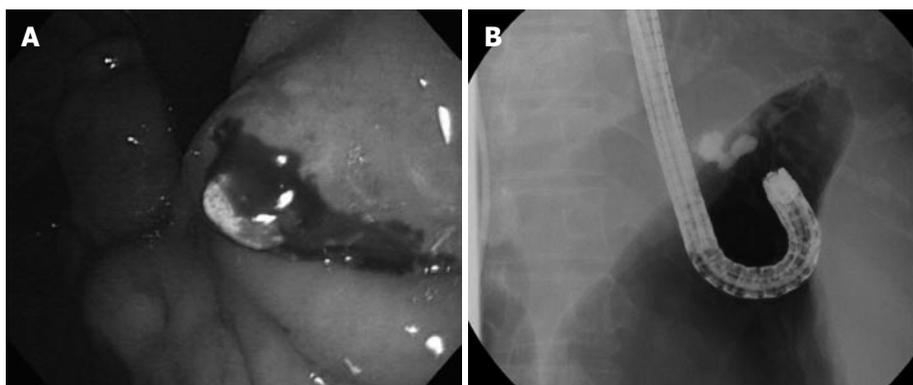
Endoscopic examination at the time of cardiac variceal rupture. A: Endoscopic examination revealed active bleeding consequent to gastric cardiac variceal rupture; B: Radiographic image of emergency endoscopic injection sclerotherapy with 5% ethanolamine oleate with iopamidol.
